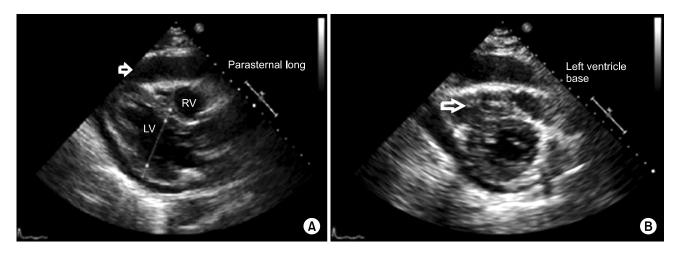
(A) TTE along the parasternal long axis: the arrows show a large pericardial effusion. (B) TTE along a short axis showing the right ventricular collapsed in diastole, suggestive of cardiac tamponade. LV, left ventricle; RV, right ventricle; TTE, transthoracic echocardiogram.
